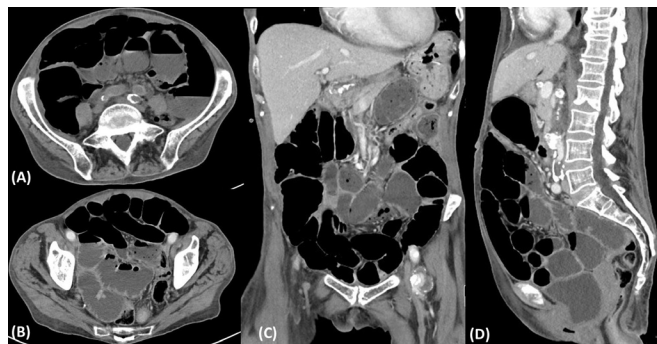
Abdominopelvic angio-CT scan of the patient during a flare of abdominal pain and bloating in axial (A, B), coronal (C) and sagittal (D) views. A marked distension of jejunum and proximal ilium loops, typically seen in cases of pseudo-obstruction, is easily identified.
